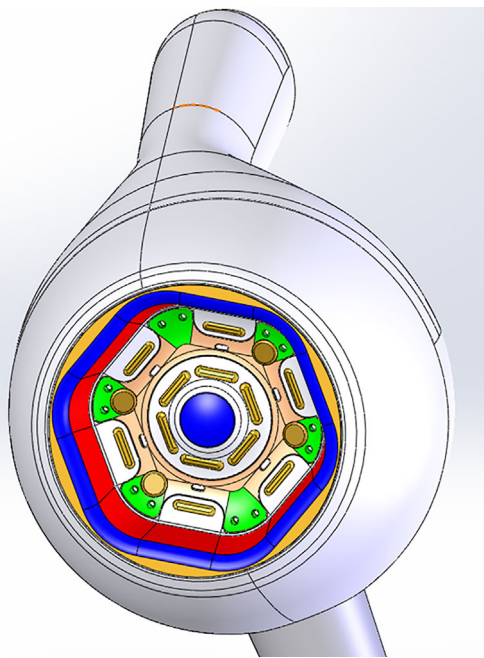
Therapeutic hand piece design: Ultrasound transmission (red), vacuum (green), cooling system (blue).
